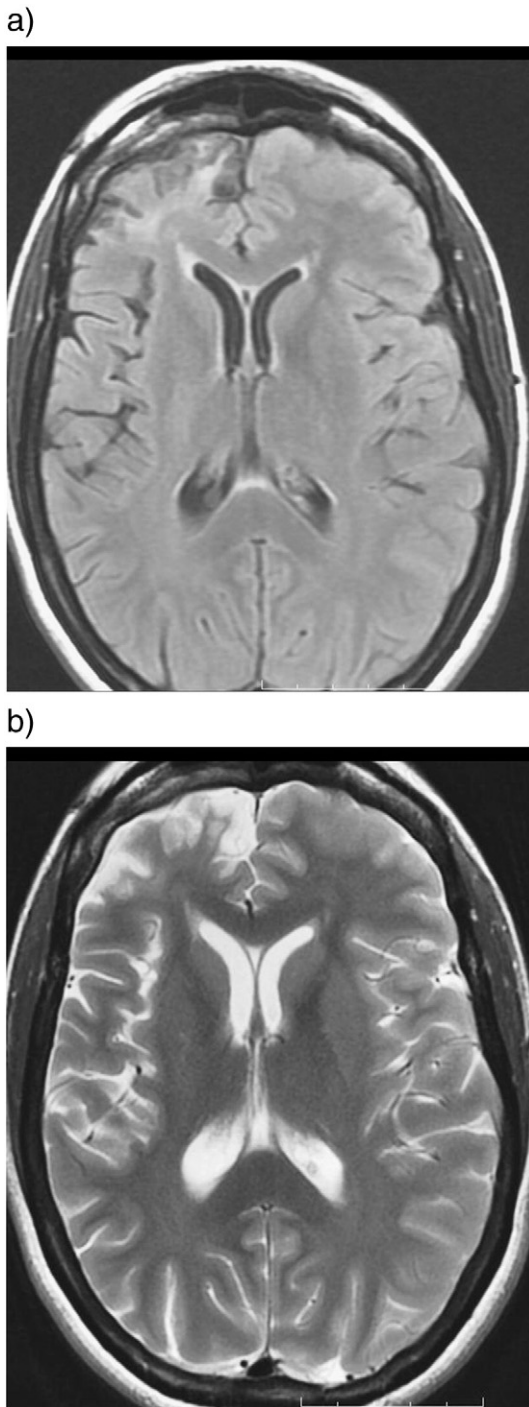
(a) Brain MRI axial FLAIR and (b) T2-weighted sequence showing encephalomalacia in the anterior right frontal lobe and another discrete noncontiguous focus of encephalomalacia involving the posterior right frontal operculum.
